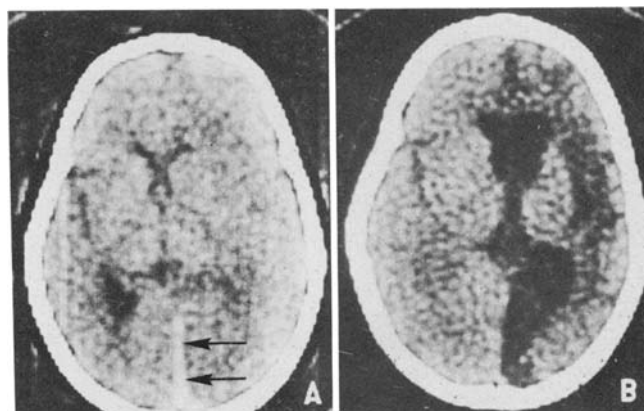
A 4-year-old girl seen after an alleged fall. On admission, she was comatose with only a pain response. Bilateral retinal hemorrhage, focal seizures, right flaccidity, and old bruises were seen. Radiographs revealed a healing fracture of the humerus, but none of the calvaria.
